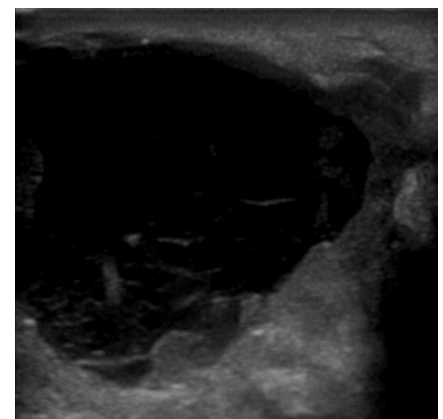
Soft tissue ultrasound, abscess. An abscess is a large, irregular fluid collection that may appear anechoic or differing echogenicities.
